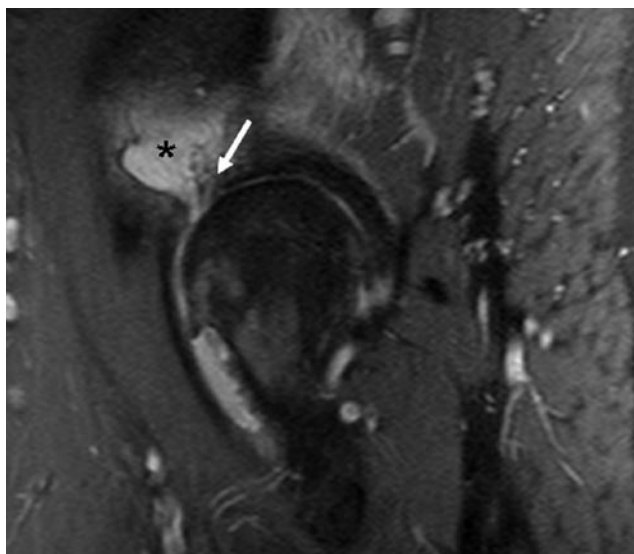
Paralabral cyst. Noncontrast proton-density fat-saturated magnetic resonance imaging of hip shows anterior acetabular labrum tear with abnormal morphology and increased internal signal (arrow). Fluid extends through the tear superiorly, forming an associated paralabral cyst (star).
